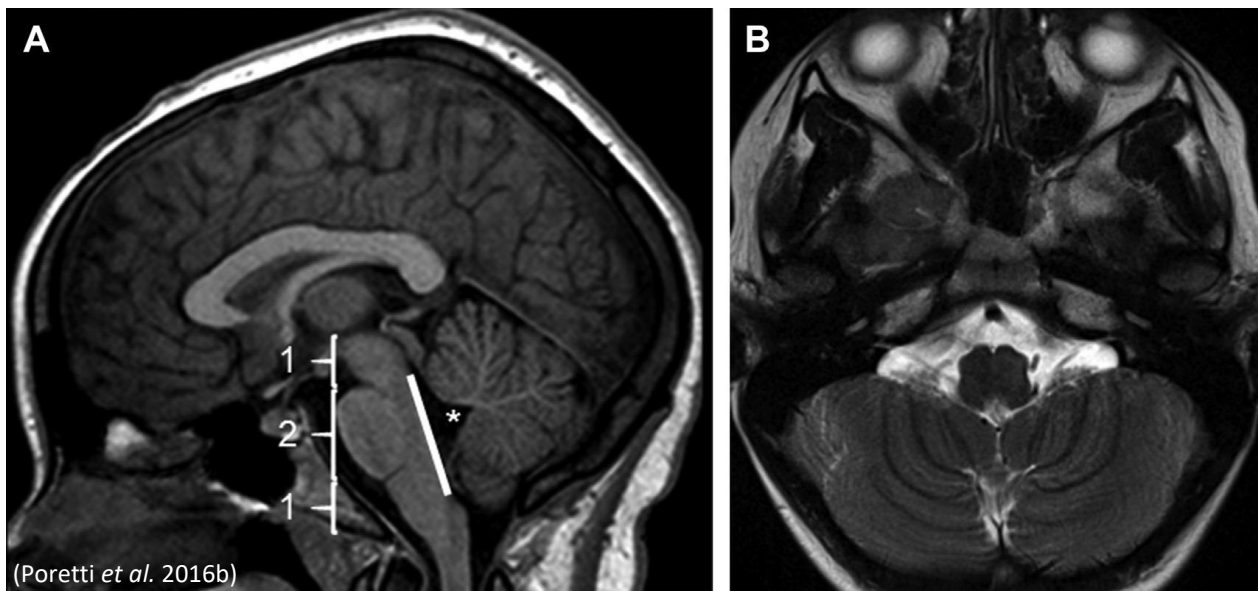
Normal MRI images of the posterior fossa. (A) Midsagittal T1-weighted MR image shows a normal-sized posterior fossa, a normal vermis, right-sized pons (the rostrocaudal length is approximately twice [2] that of the midbrain [1] and medulla [1]), a flat dorsal surface of the brainstem (*line*) and an appropriately positioned fastigium just below the midpoint of the ventral pons (*asterisk*). (B) Axial T2-weighted MR image shows normal orientation of the cerebellar folia, running parallel to the calvaria (onionlike orientation).
